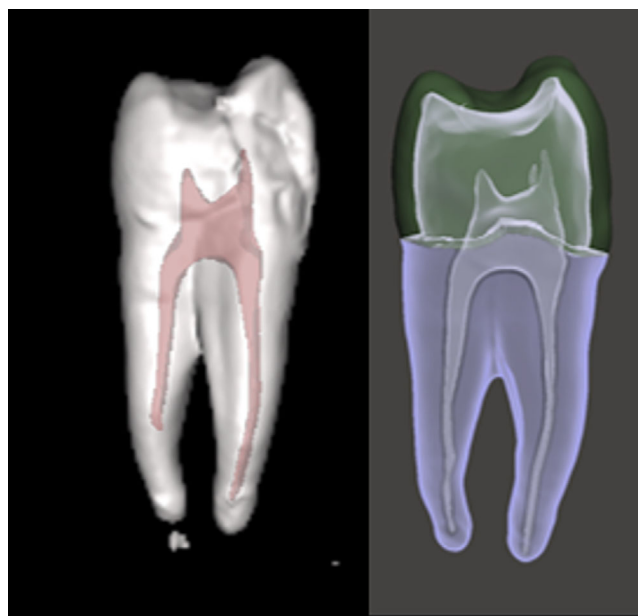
Cone beam computed tomography (CBCT) and segmented Standard Tessellation Language (STL) files.
